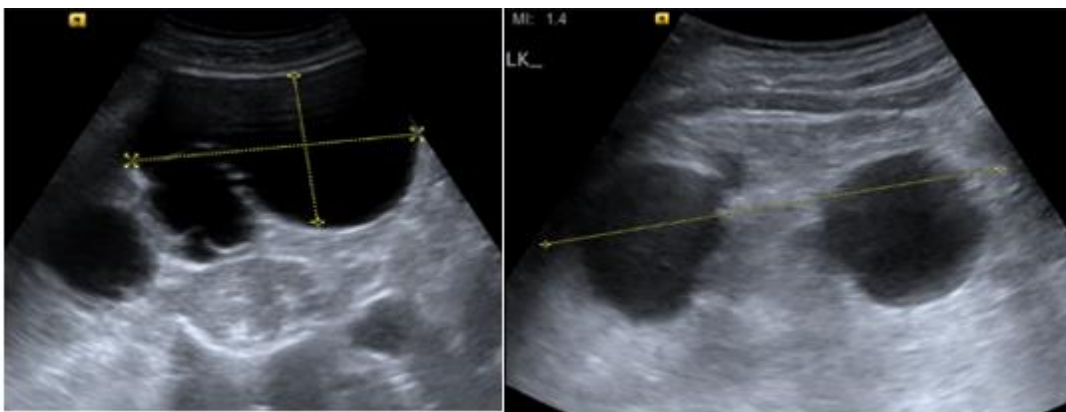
Ultrasound Showing bilateral enlarged kidneys with multiple cysts of varying sizes
